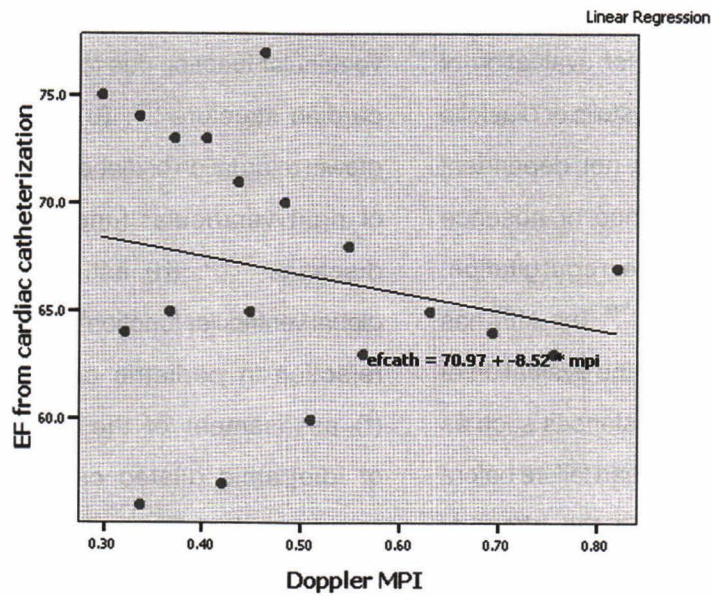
Correlation between Doppler myocardial performance index (MPI) and ejection fraction from cardiac catheterization.
